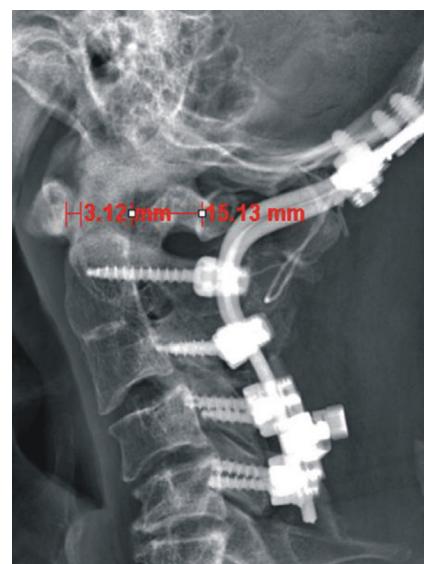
Immediate postoperative lateral X-ray showing a 3.12 mm atlanto-dens interval and a C1 canal diameter of 15.13 mm. Iliac bone block with wiring between the occiput and C2 is also visible.
